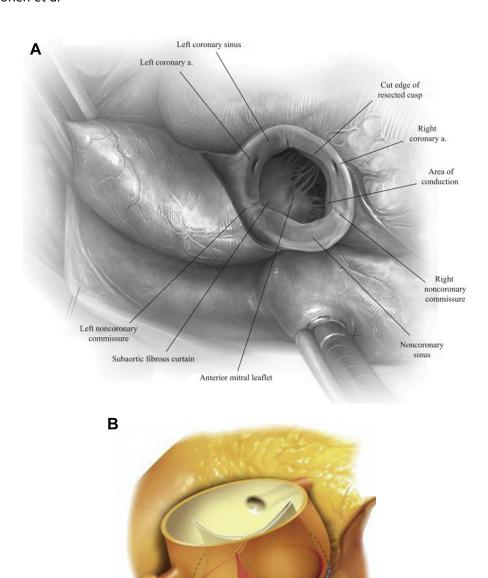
(*A*) Anatomy of the aortic root shows the valve cusps have been excised to show the aortic annulus and aortic outflow tract. (*B*) Anatomy of the aortic root shows the aortic root with aortic valve intact. (*Adapted from* [*A*] Grubb, KJ. Aortic root enlargement during aortic valve replacement: nicks and manouguian techniques. Oper Tech Thorac Cardiovasc Surg 2015;20(3):206–18, with permission; and [*B*] Holubec T, Higashigaito K, Belobradek Z, et al. An expansible aortic ring in aortic root remodeling: exact position, pulsatility, effectiveness, and stability in three-dimensional CT study. Ann Thorac Surg 2017;103(1):83–90, with permission.)
